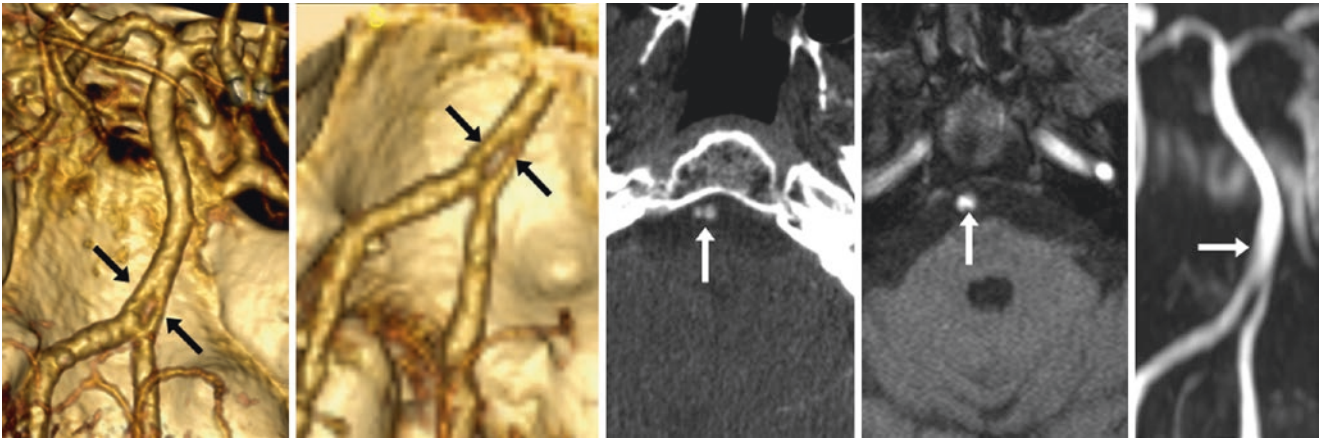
47-year-old with a lower basilar fenestration (*arrows*) just above the vertebrobasilar confluence on a CTA with posterior views (*left and left middle*). The cleft was clearly seen on axial source images from the CTA (*middle*), but not on 3D TOF MRA axial source images (*right middle*), or on an MRA MIP AP view (*right*)
